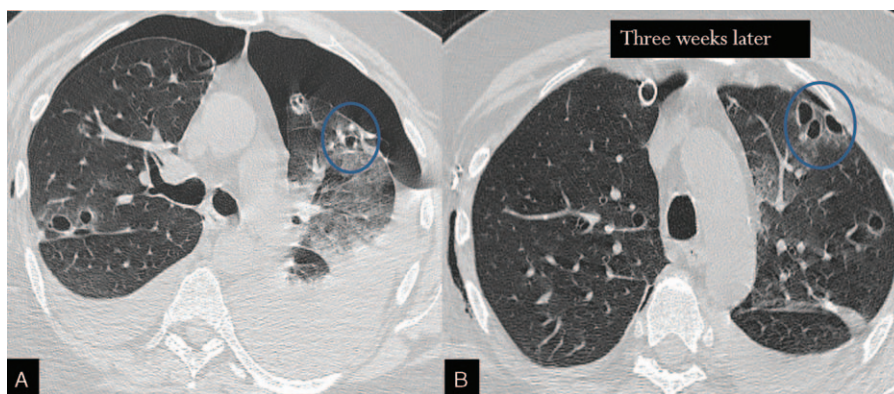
Patient 4. Comparison between baseline CT scan and control 3 weeks later shows that the cystic lesions are bigger and more numerous than the prior, suggesting a rapid disease progression. Moreover, nodules that were visible in the prior examination now have a cystic shape (blue circle). Informed consent from patients was obtained.
